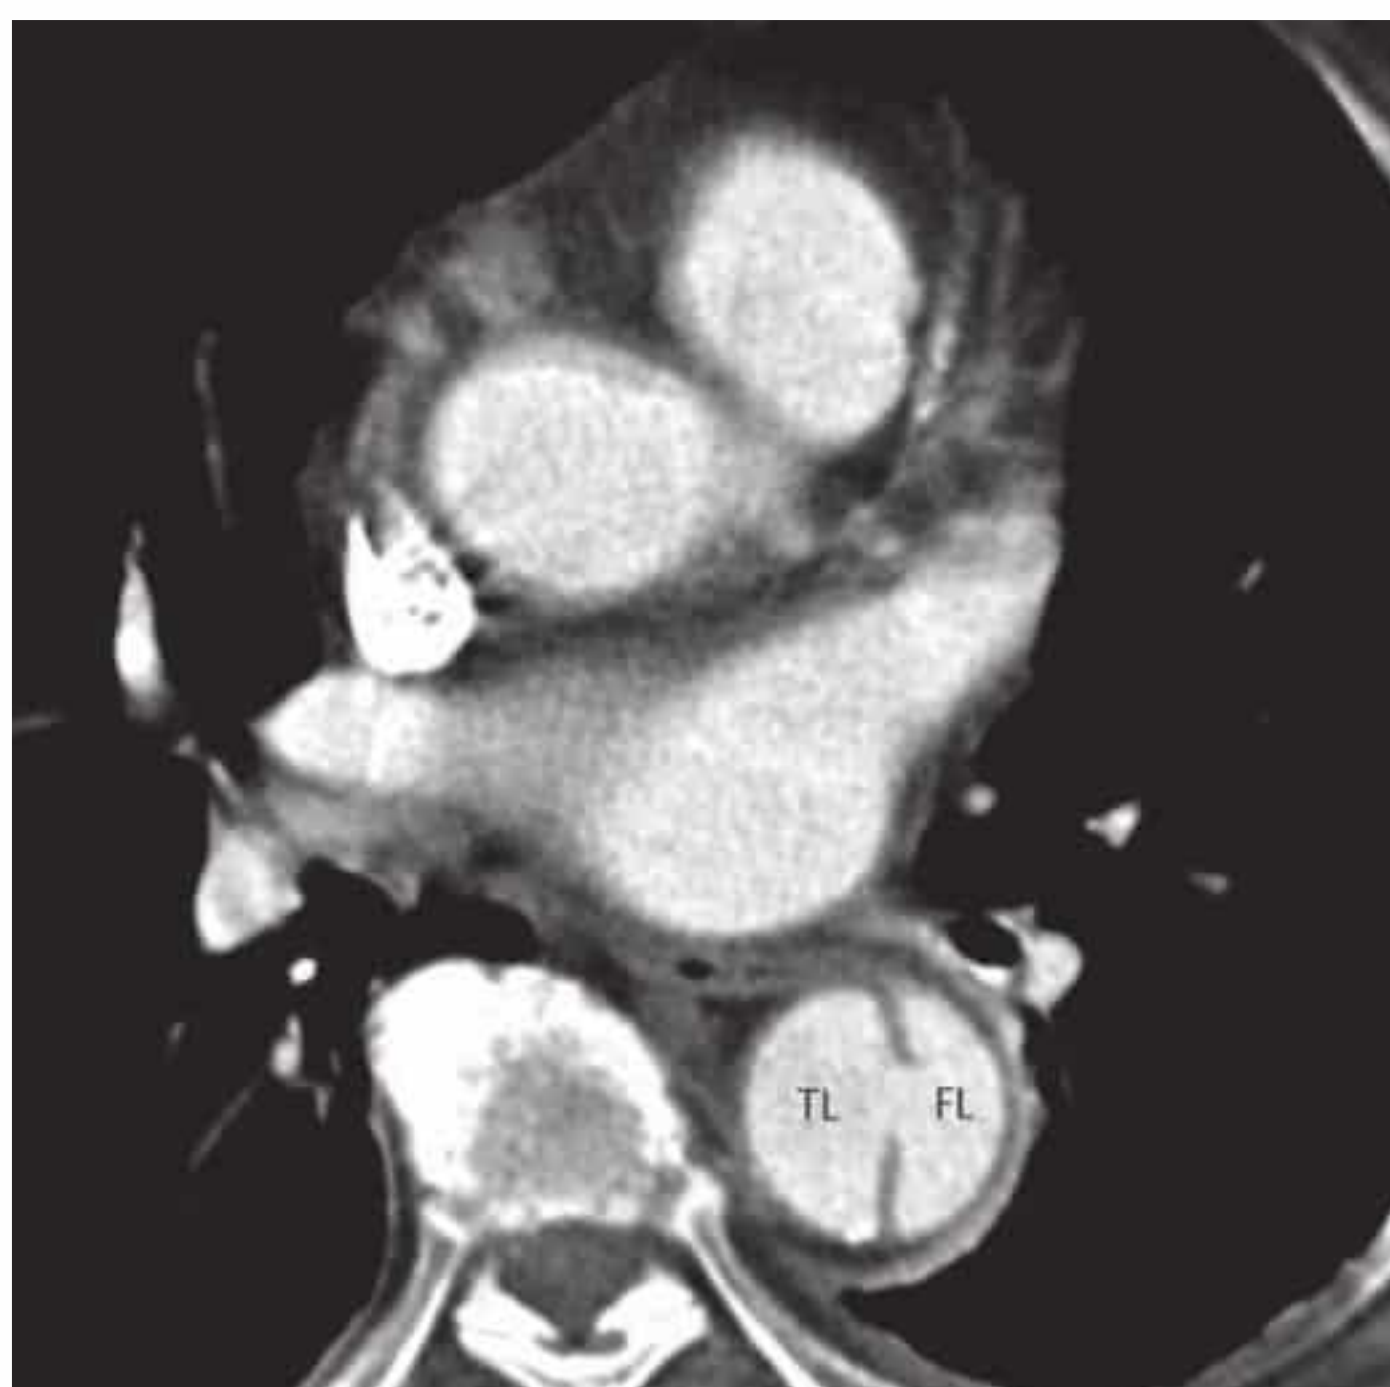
Contrast-enhanced CT reveals a large entry between true (TL) and false (FL) lumina.
